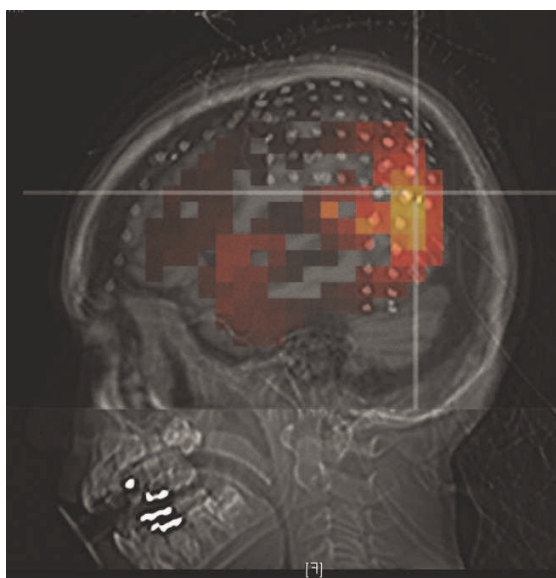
Source analysis of onset of seizure of subject shown in Fig. 2, co-registered on standard MRI model suggests origin in left parietal cortex (yellow color, with maximal intensity at crosshairs). The figure is also co-registered with subsequent computed tomography showing intracranial electrode placement. Invasive studies revealed left parietal cortical origin of the subject's seizures.
